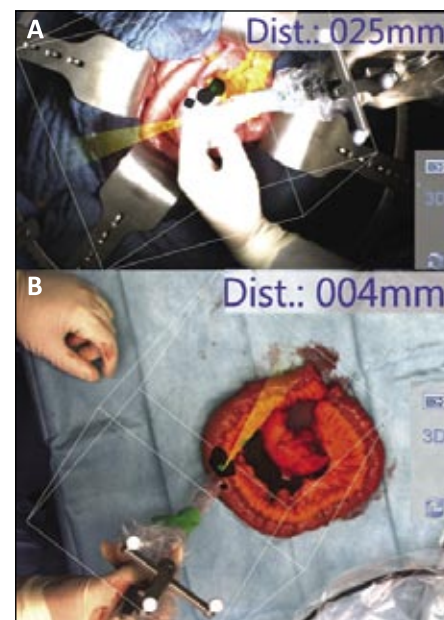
Intraoperative probe-guided 3D navigation for targeted tumor resection. (A) Radiolabelling of a neuroendocrine tumor using ^{111}In -octreotide and subsequent visualization using infrared cameras and freehand-SPECT technology. Due to the specific retention of the radiotracer in the tumor, the latter can be identified during the procedure. After resection (B), complete removal of tumor tissue can be verified by another probe assessment.
